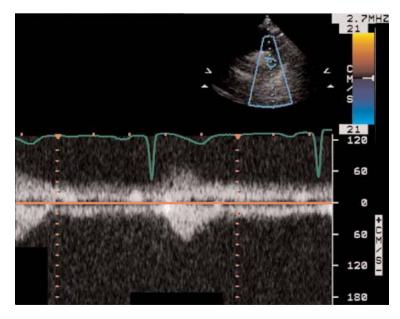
Patent ductus arteriosus. Pulsed Doppler interrogation at the site (same patient, Fig. 20) shows continuous low velocity flow with systolic accentuation.
